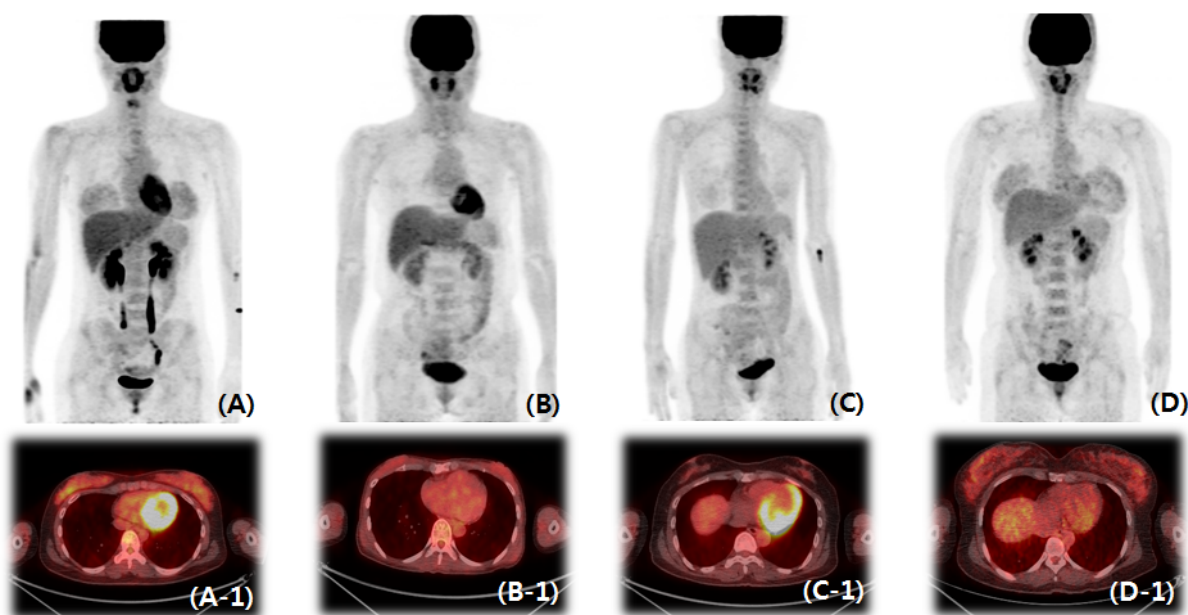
Breast uptake values increased in order of secretory, flow, and ovulatory phase, similarly. Proliferative phase showed comparative low SUVs, only.
